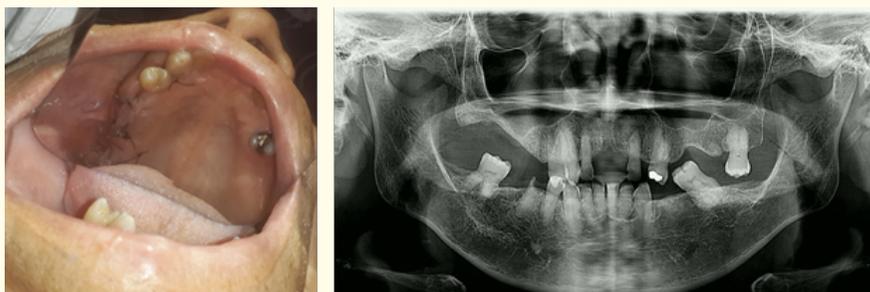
Post-operative: a. Intraoral photography where frank scarring of the post-surgical zone is evident, without the presence of fistulas or secretions. b. Panoramic X-ray.
